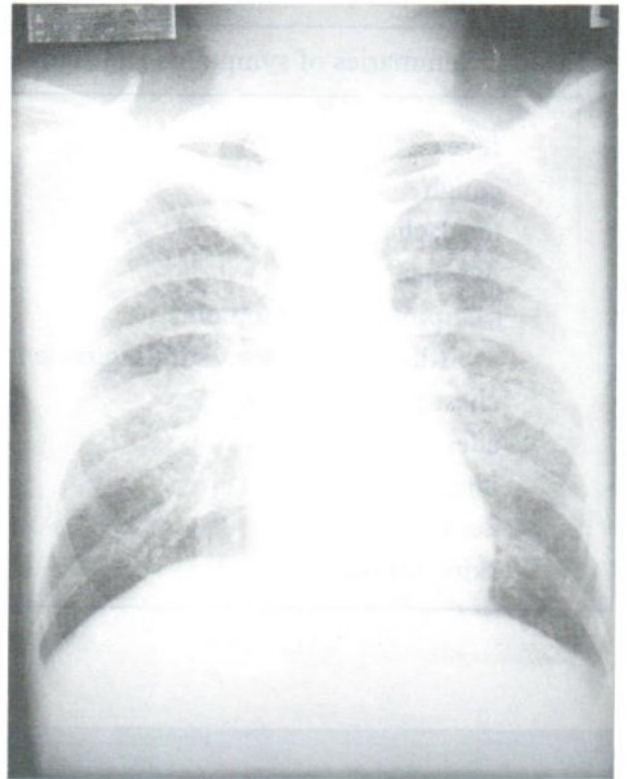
Chest radiograph shows coarse reticular infiltration in both lungs.
